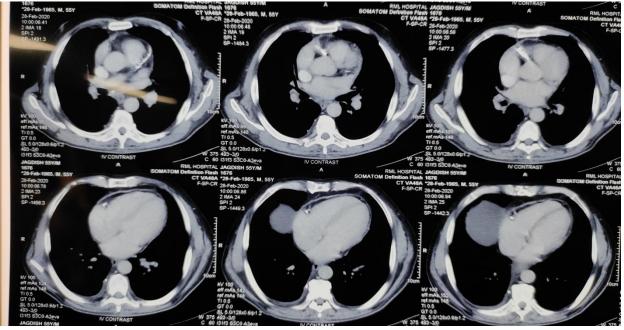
Cardiac CT showing pericardial calcification
